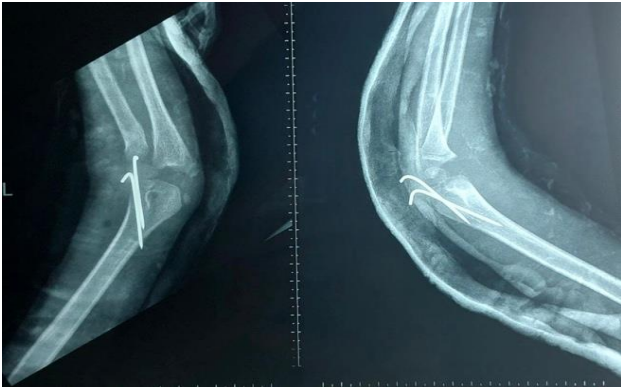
Post op X-ray of case 1 (fixed by 2 K-wires).
